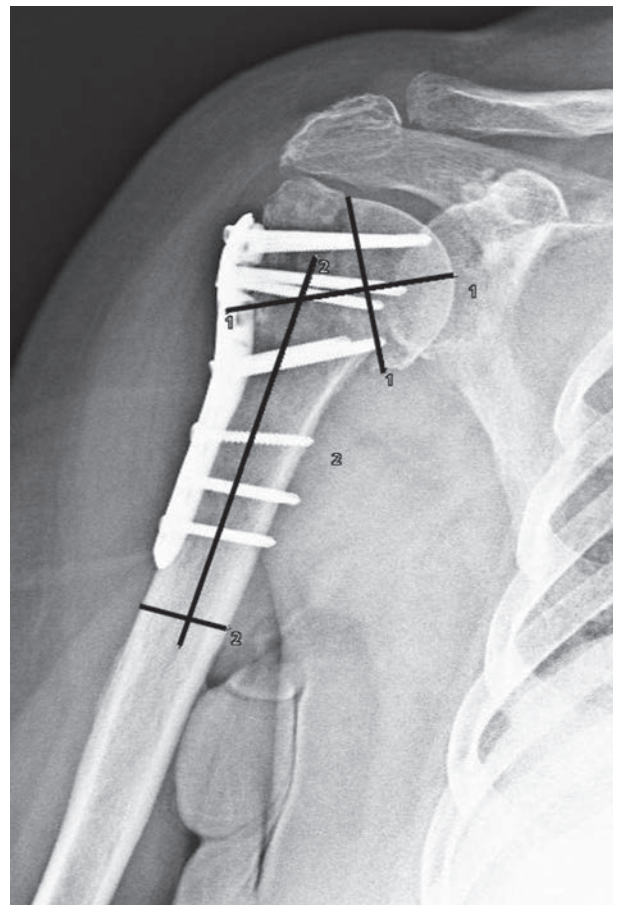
Radiograph at 1 month of follow-up showing progressive loss of reduction of the head ($117,56^\circ$)
